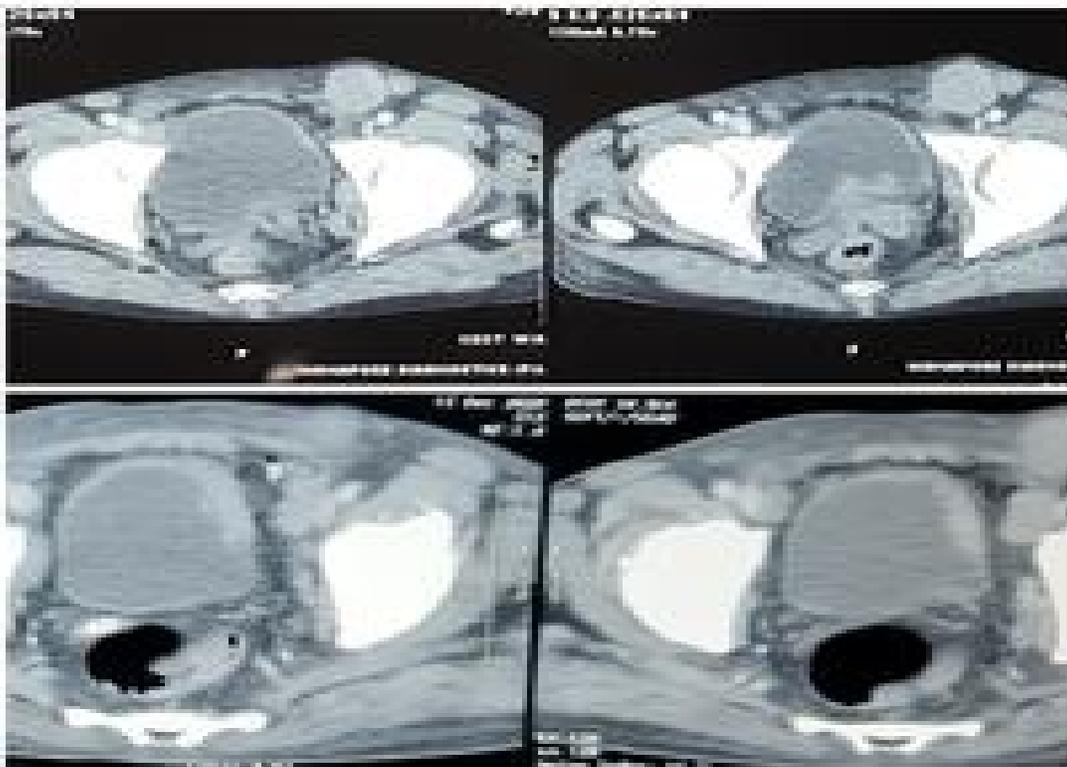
CT scan showing irregular bladder wall thickening in the anterior and left lateral bladder wall with multiple inguinal and femoral lymphadenopathy
